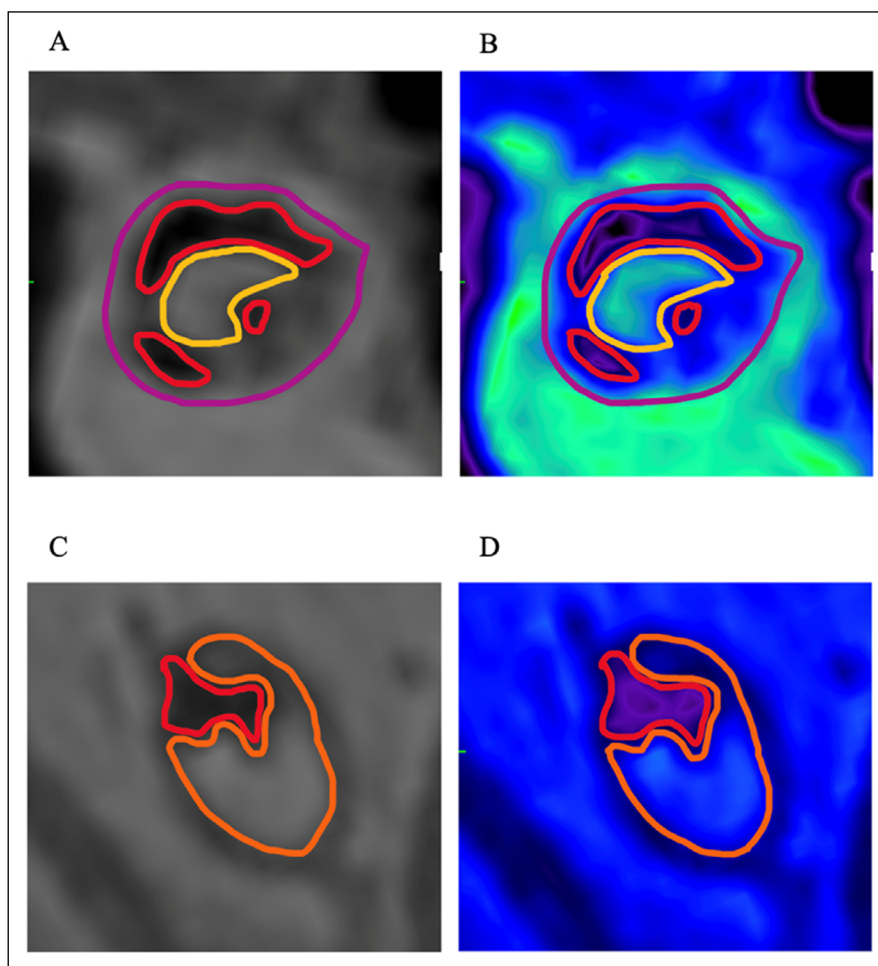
(A,B) Conventional greyscale and color-coded ultrashort echo time magnetic resonance imaging (UTE MRI) images of stenotic lesion; yellow outline: patent lumen; purple outline: thickened vessel wall with lipid rich and collagenous deposits typical in atherosclerosis; red outline: concentric and central calcium deposits. (C,D) Conventional greyscale and color-coded UTE MRI images of occlusive lesion; orange outline: soft collagenous component; red outline: eccentric calcium deposit.
